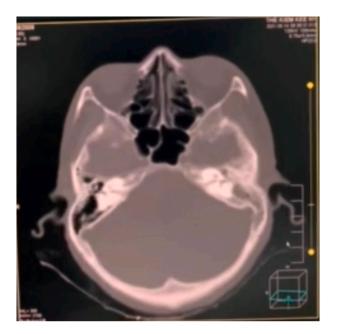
Head CT-scan revealed features suggestive of multiple brain abscess.
